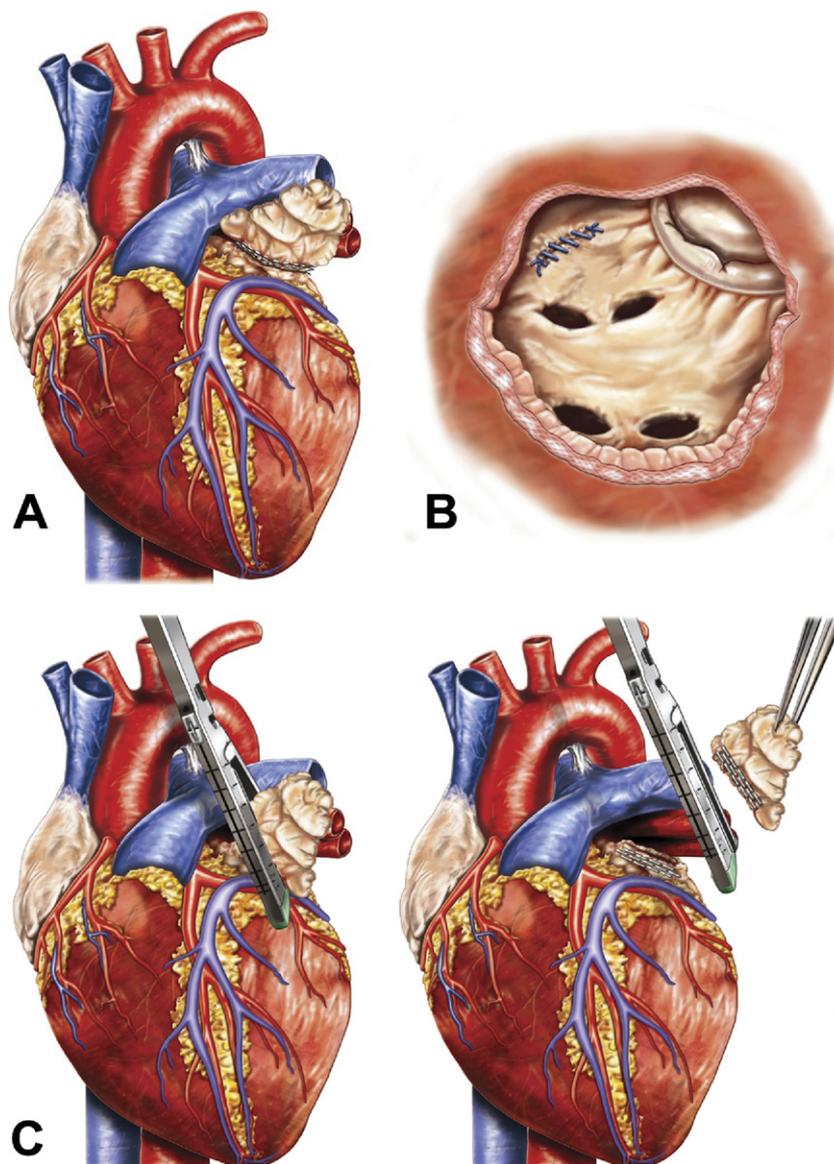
Surgical techniques of left atrial appendage (LAA) closure. (A) Epicardial suture exclusion. (B) Endocardial suture exclusion. (C) Stapled excision. (Left panel) Stapler positioned across the base of the LAA; (Right panel) LAA removed with intact stump. Studies suggest the residual stump may be too large. (D) Excision by removal and oversew. (Left panel) Lateral wall of the heart is elevated to bring the LAA into view; (Middle panel) Removal of the LAA by scissors (pictured) or electrocautery with a < 1 cm stump for closure; (Right panel) Two-layer suture closure of the LAA stump flush with the heart surface. (E) Transesophageal echocardiogram shows no flow after removal and oversew. (F) View from inside the left atrium after removal and oversew demonstrates complete closure.
